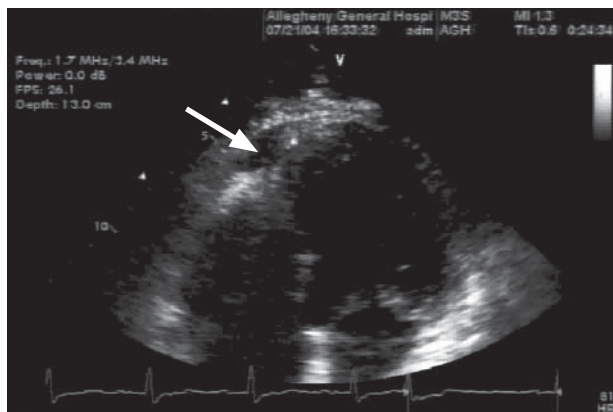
Two-dimensional echocardiogram (modified 4-chamber view) shows an ill-defined hypoechoic zone (arrow).
